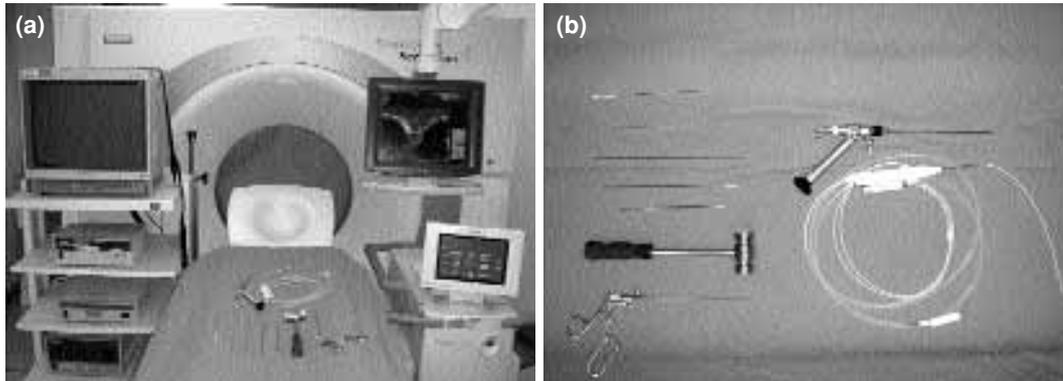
Operation room set up. (a) Interventional CT (Somatome Sensation 4, Siemens) and Ho:YAG laser-assisted endoscopic system. (b) Surgical instruments and laser-assisted spinal endoscopy (LASE) kit.
